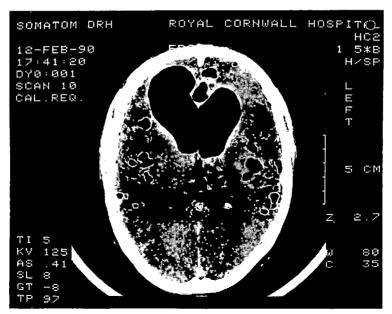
CT brain scan showing a large intraventicular and smaller subarachnoid aerocoeles. The lateral ventricles are dilated and there is air over the brain surface.
